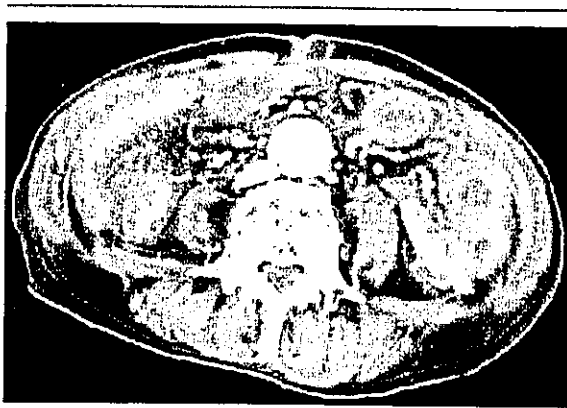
The computed tomography on admission. The computed tomography on admission showed the thickness of the intestinal wall, however, the blood supply to the mucosa was normal.
